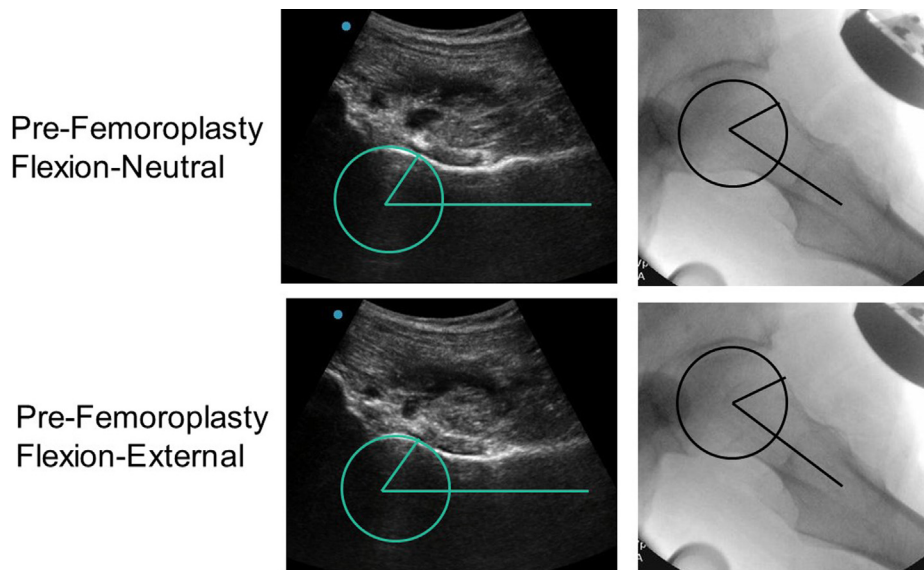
Ultrasound (left) and fluoroscopic (right) images of left hip of operative patient on traction table in supine position prior to femoroplasty. The different views of the femoral neck pathology with different rotations (flexion-neutral and flexion-external rotation) can be appreciated, as can the similarity between ultrasound and fluoroscopy. Blue dot denotes superior anatomic position.
